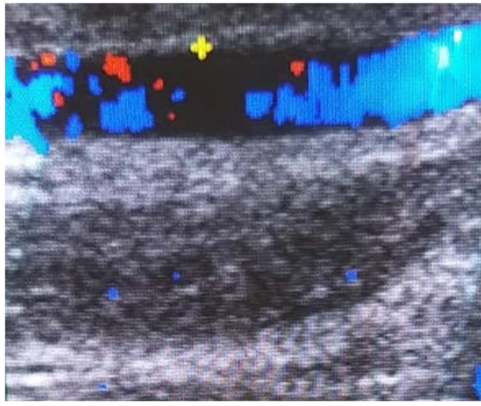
The longitudinal view of doppler ultrasound shows high-flow superficial vasculature within the skin lesion in the index baby.
